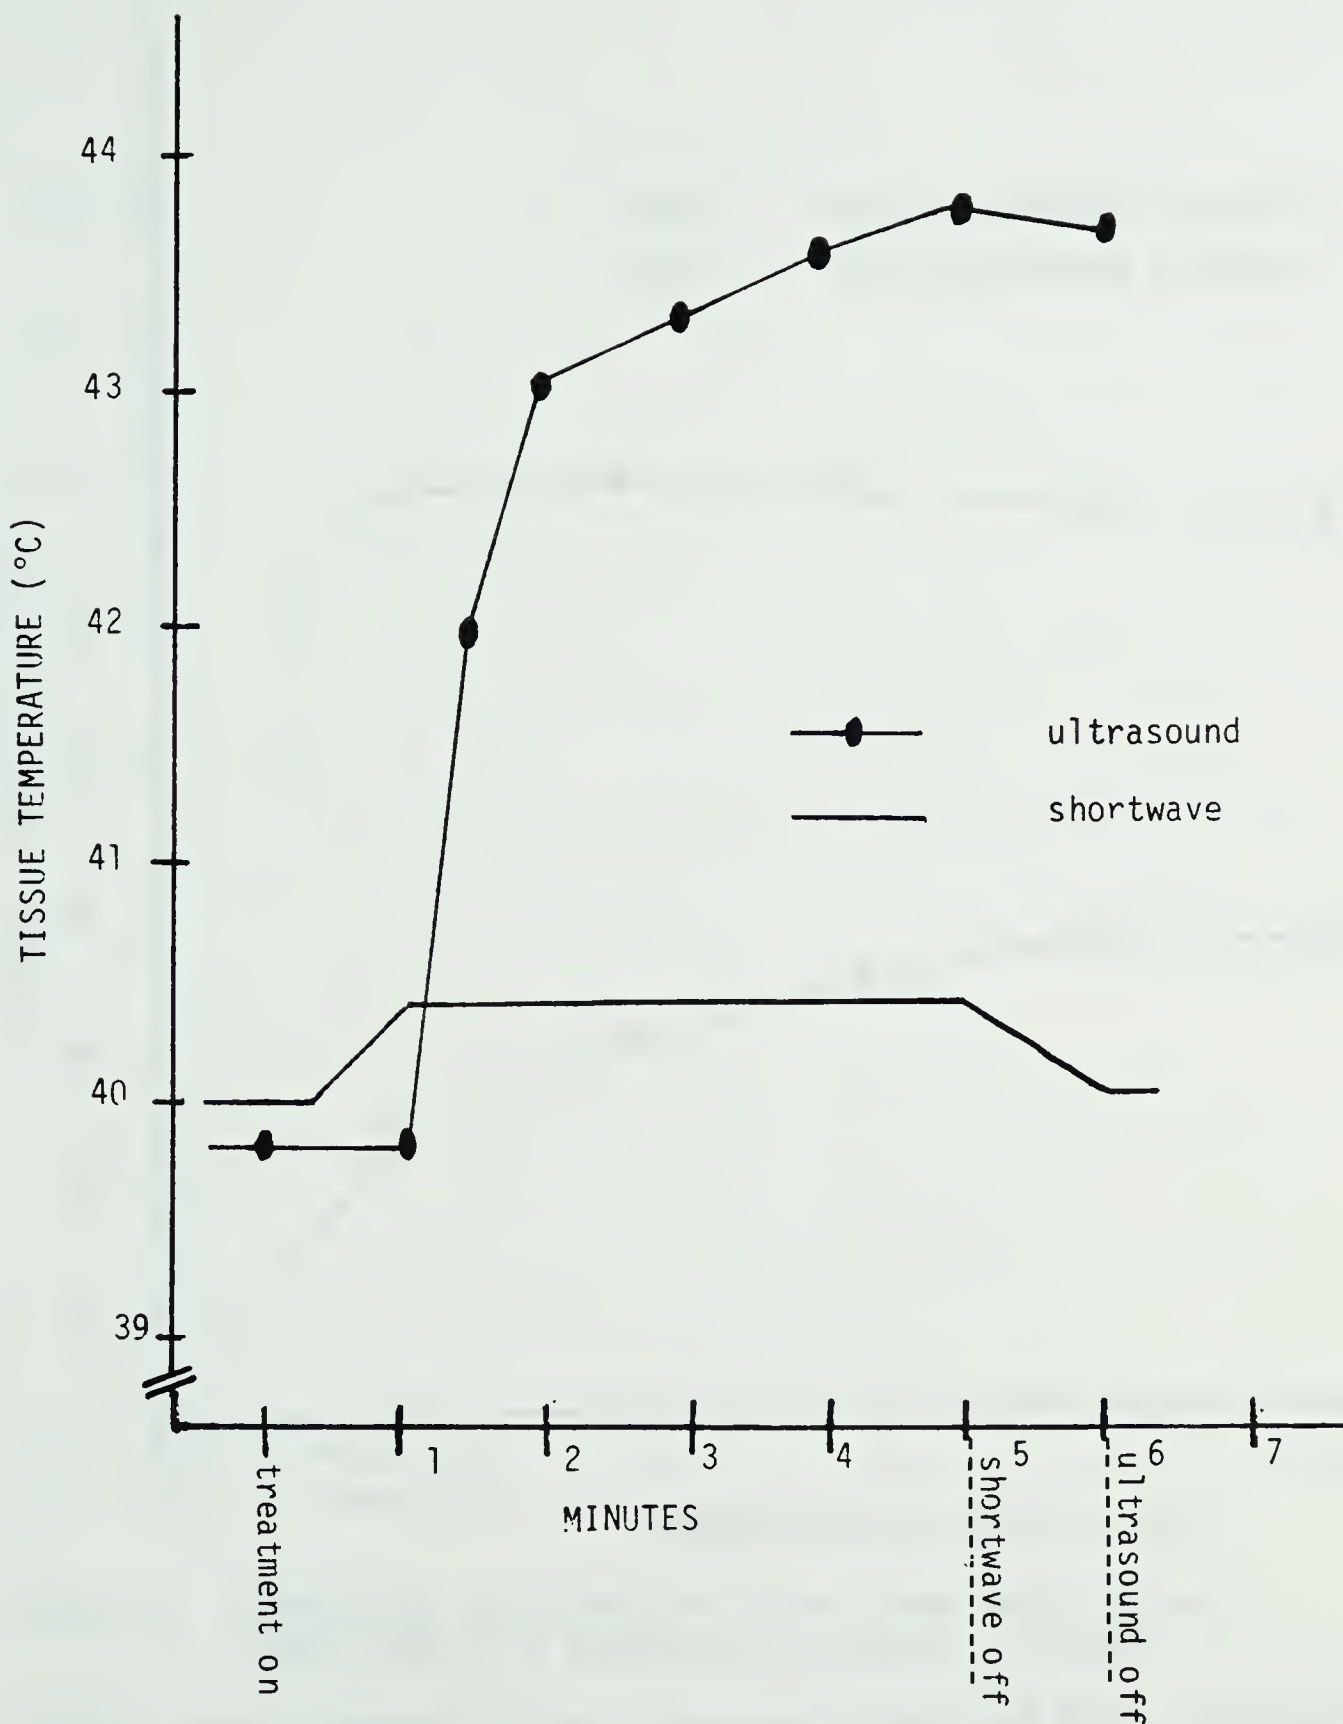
CHANGE IN TEMPERATURE INSIDE THE HIP JOINT FOLLOWING THE APPLICATION OF SHORTWAVE DIATHERMY AND ULTRASOUND
